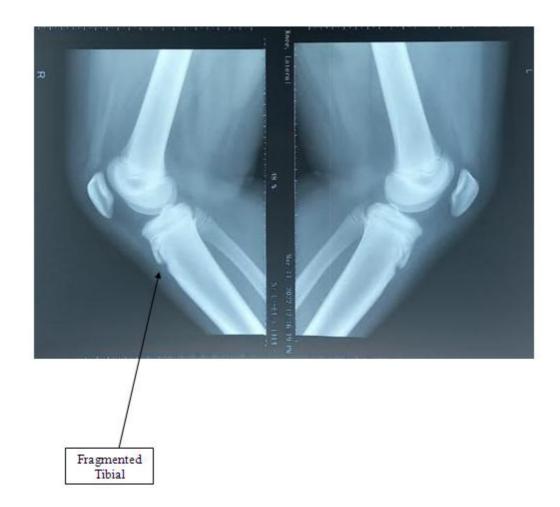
Lateral knee radiograph of Osgood-Schlatter disease showing fragmented tibial
